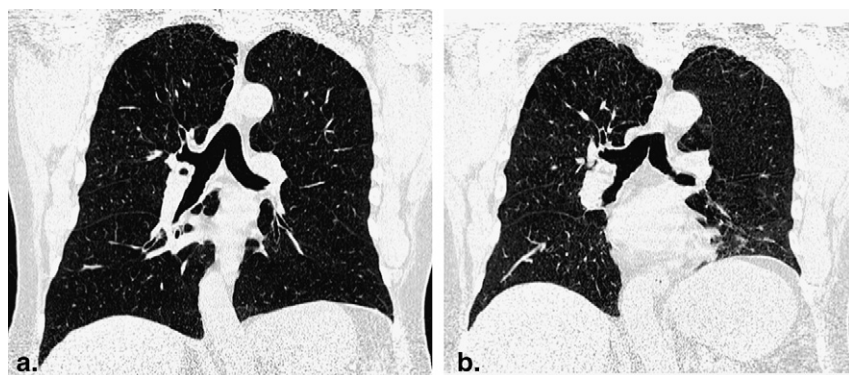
A 69-year-old man with chronic obstructive pulmonary disease (Global Initiative for Chronic Obstructive Lung Disease [GOLD] stage 2) Reconstructed coronal computed tomography (CT) images, which are made by the software, at full inspiration (a) and full expiration (b) are shown. Lung volume (LV) expiratory/inspiratory (E/I) ratio is 0.70, and mean lung density (MLD) E/I ratio is 0.95. Note that LV is calculated based on all axial images, not on the coronal images.
